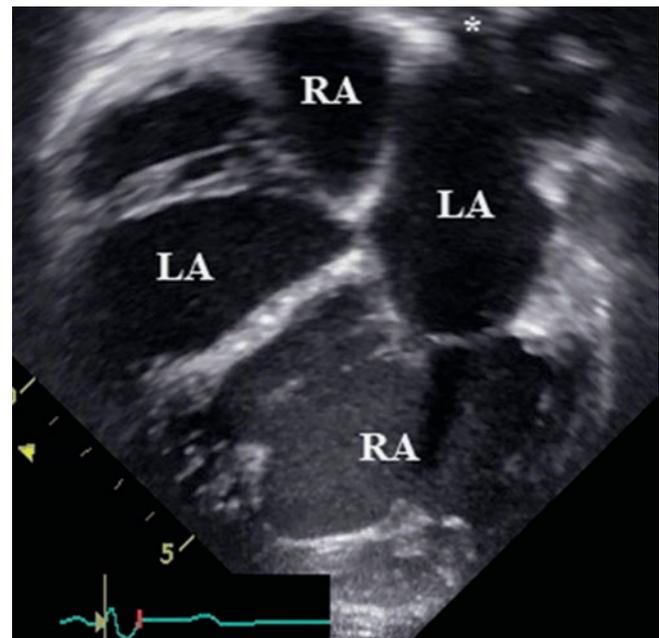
ccTGA. Apical 4-chamber view in a patient with congenitally corrected transposition of the great arteries (atrio-ventricular; ventricular arterial discordance). The pulmonary veins (*asterisk*) drain into the left atrium, which connects through the more apically displaced tricuspid valve to the morphologic right ventricle (RV), situated on the left. The right atrium (RA) connects through the mitral valve to the morphologic left ventricle situated on the right
